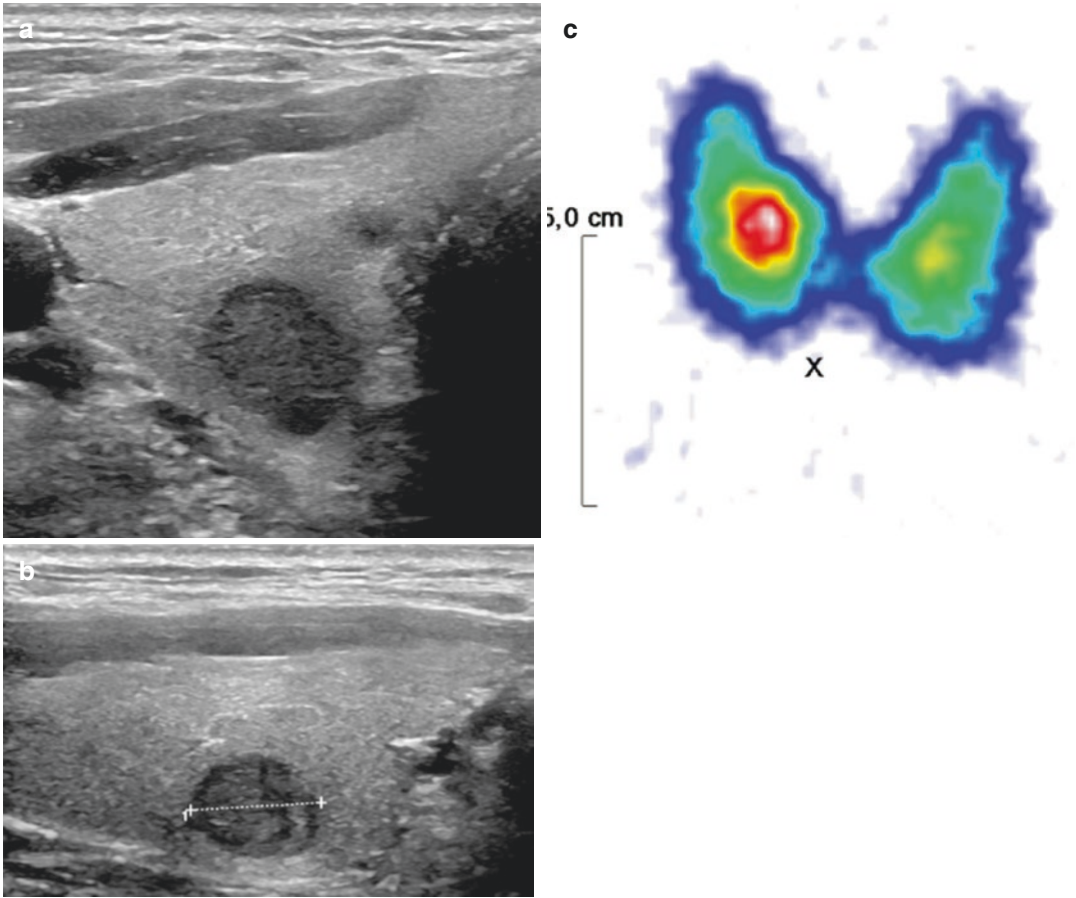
(a–c) This 60-year-old man has a solitary hypoechoic and solid nodule ($10 \times 11 \times 12$ mm) in the dorsal right thyroid lobe (a). The configuration of the nodule is slightly taller than wide which may be triggered by the gross protrusion of the thyroid lobe toward the back (b, EU-TIRADS 5). Formally, this nodule exhibits three of five ultrasound risk factors making FNAC necessary.
